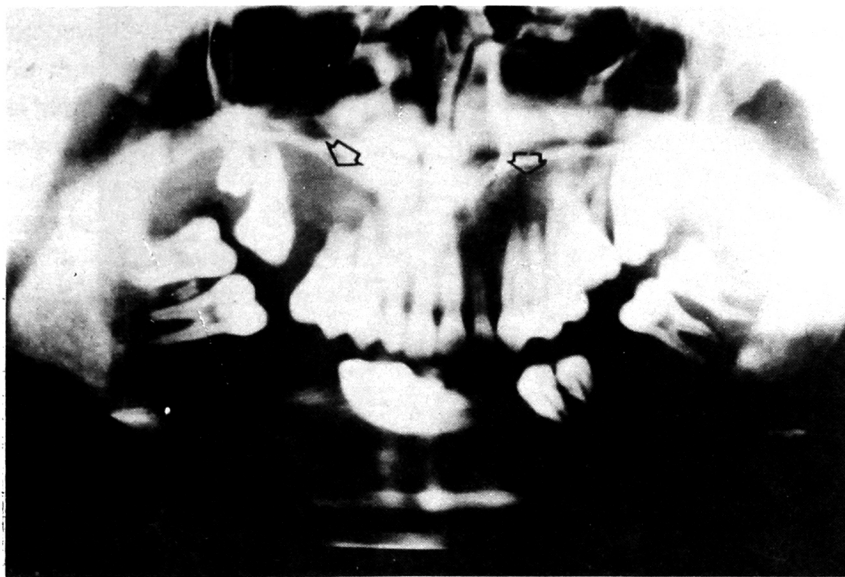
Orthopantomogram showing bone destruction extending from left to right body of the mandible, maxilla area#16 to right tuberosity and periapical area # 23-25 (arrows).
